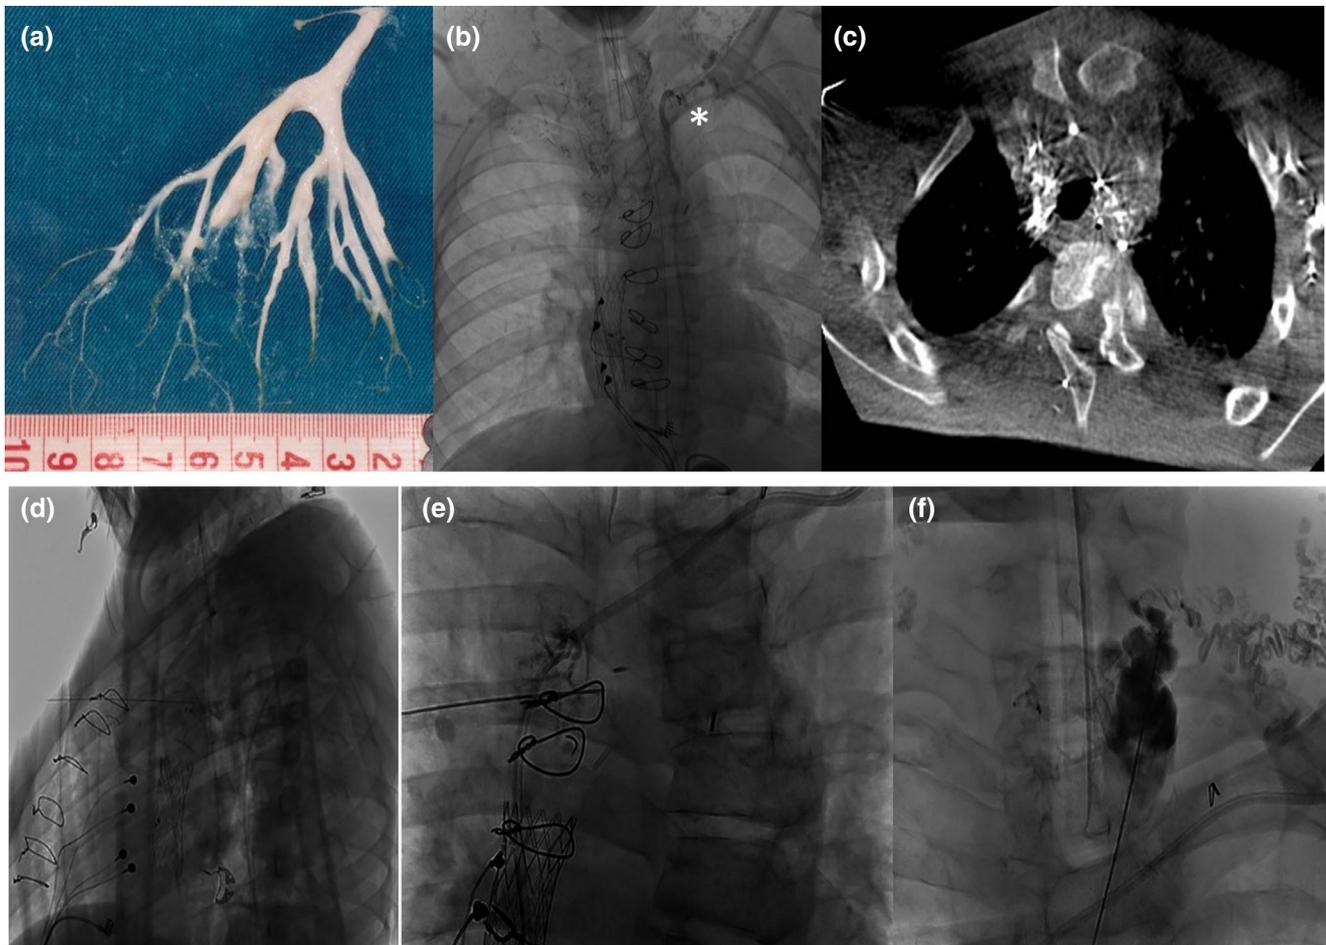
Plastic bronchitis. (a) Expectorated cast of bronchial tree in Fontan patient with PB plastic bronchitis. (b) Lymphography after inguinal intranodal Lipiodol injection: thoracic duct is opacified and a surgical clip is observed at the junction with subclavian vein (accidentally placed during neonatal coarctectomy*)—note progression of Lipiodol contrast in upper mediastinal lymphatics. (c) Cone-beam computer tomography of mediastinum after inguinal Lipiodol infusion: thoracic duct, with contrast in multiple dilated lymph vessels. (d) Lateral view percutaneous direct transthoracic cone-beam computer tomography guided puncture of paratracheal lymph vessels with 22G Chiba needle. (e) Frontal view of puncturing at right side of trachea. (f) Paratracheal puncture on left side [Color figure can be viewed at wileyonlinelibrary.com]
